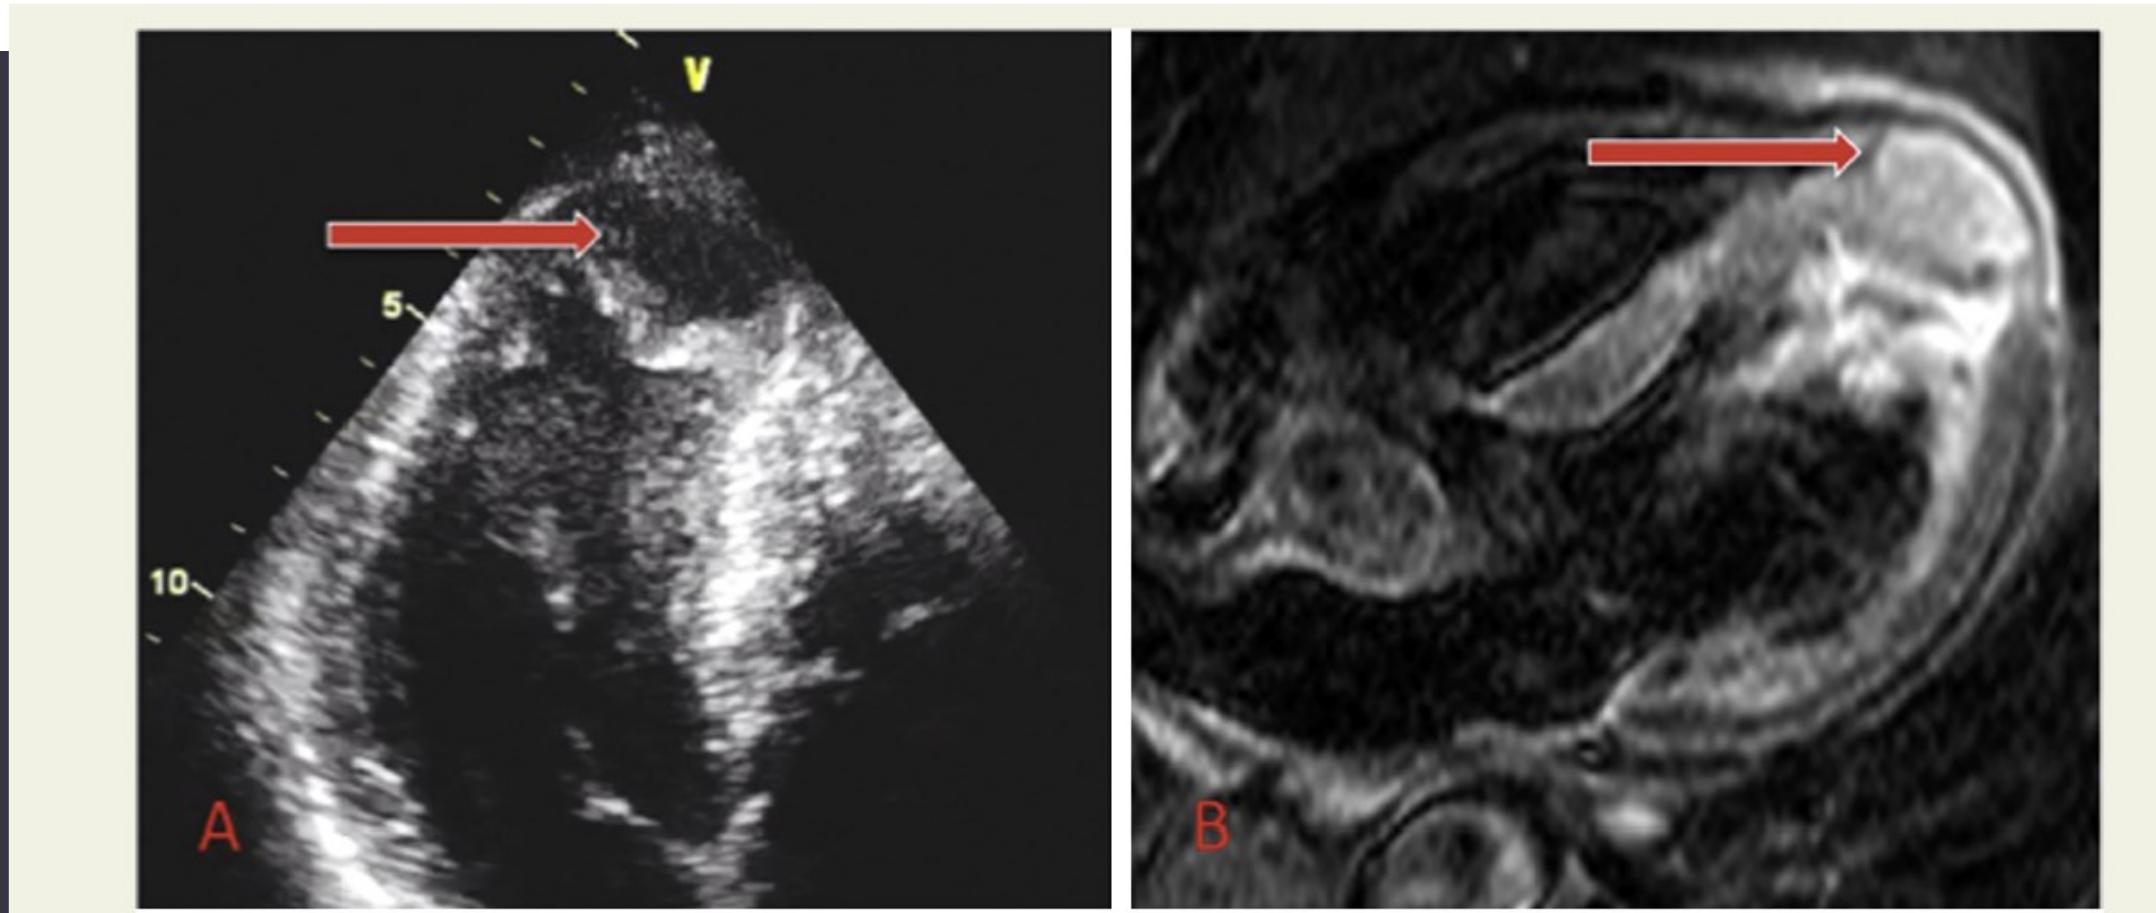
A: Contrast Trans-thoracic Echocardiography showing a large apical thrombus, separated from LV cavity by the myocardium.
